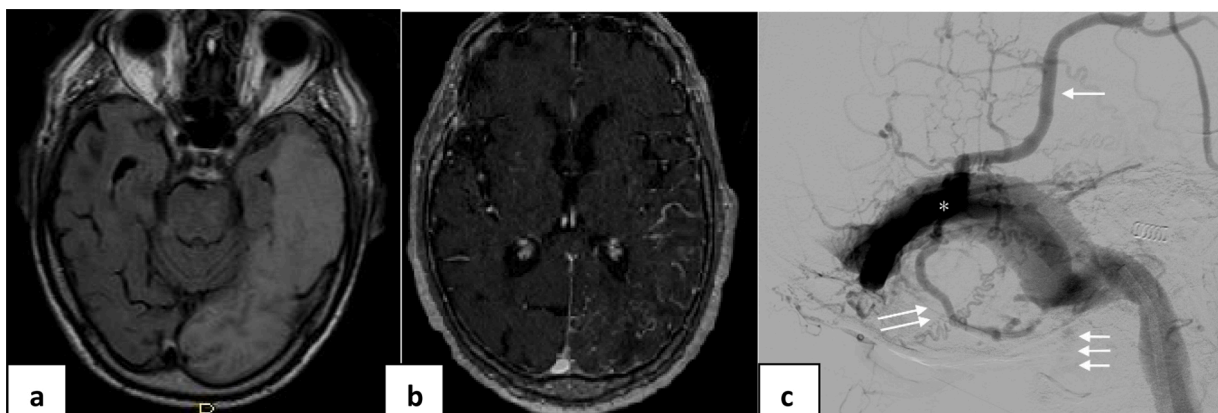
Radiological findings. (a) MRI axial T2-FLAIR. Cortical-subcortical hyperintensity in left temporal, occipital lobe, ponto-mesencephalic regions due to congestive edema and venous hypertension without any arterial distribution. (b) MRI axial post-contrast T1 MPRAGE. Multiple dilated pial vessels in the sub-arachnoid space related to venous reflux with cortical or deep venous drainage. (c) Cerebral Angiography. Lateral view of the left external carotid artery. Asterisk: fistula point on left transverse sinus. Single arrow: vein reflux on homolateral Labbè Vein and in other supratentorial cortical veins. Double arrow: vein reflux in the infratentorial veins of the left cerebellar hemisphere. Triple arrow: absence of left jugular vein due to thrombosis.
